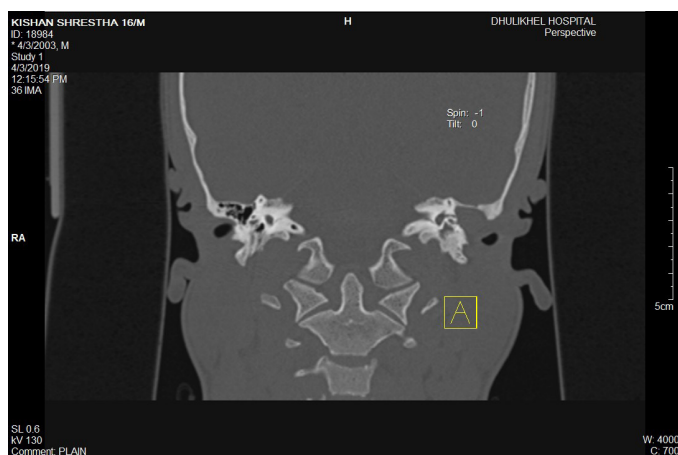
High resolution computed tomography showing left lateral SCC fistula
